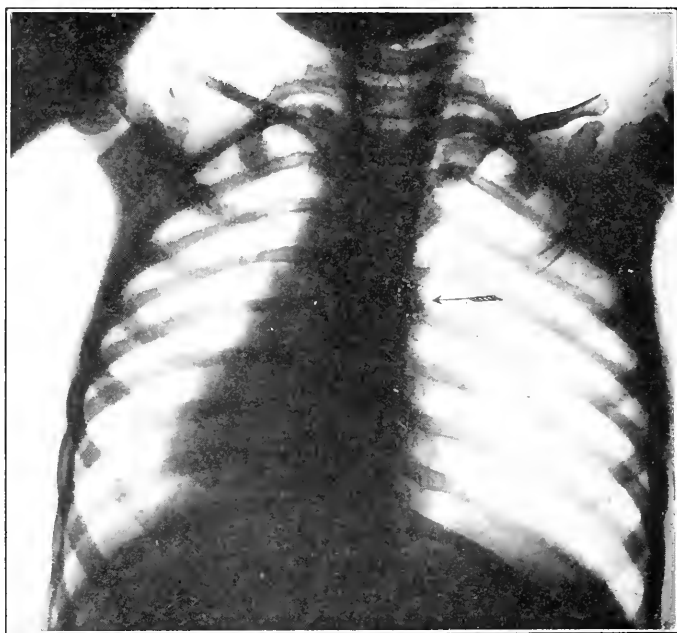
Radiograph showing pebble in right bronchus of a child, aged four years. The “asthmatoïd wheeze” was absent in this case, presumably because the pebble (Fig. 2) “corked” the bronchus so completely that no air could pass. (Radiograph made by Drs. Manges and Bowen. Case No. Fbdy. 624.)
